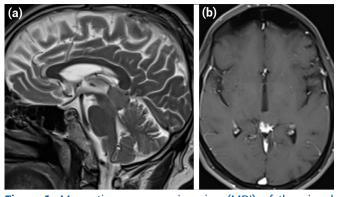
Magnetic resonance imaging (MRI) of the pineal glioblastoma at initial presentation (a) Sagittal T2-weighted image shows a mass in the pineal region (b) The mass shows heterogeneous enhancement on postcontrast axial T1-weighted image.
